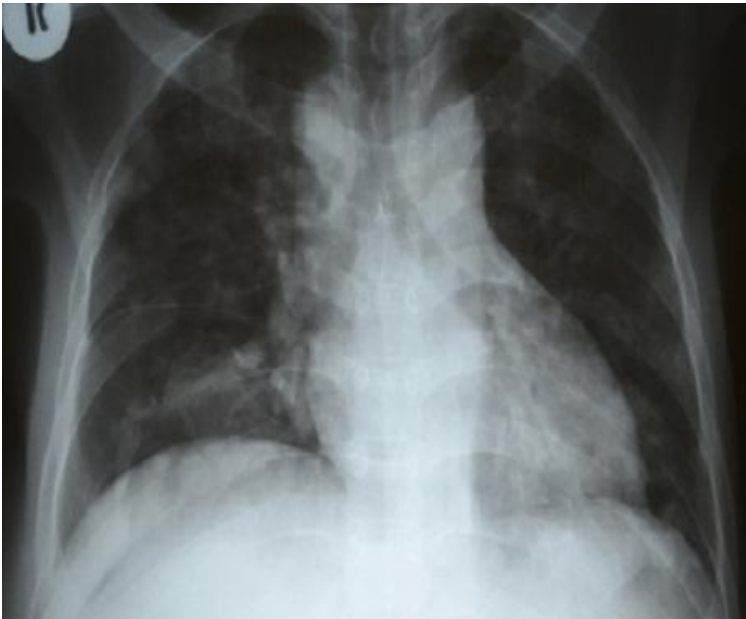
chest x-ray showing nodular opacities in both lung fields
